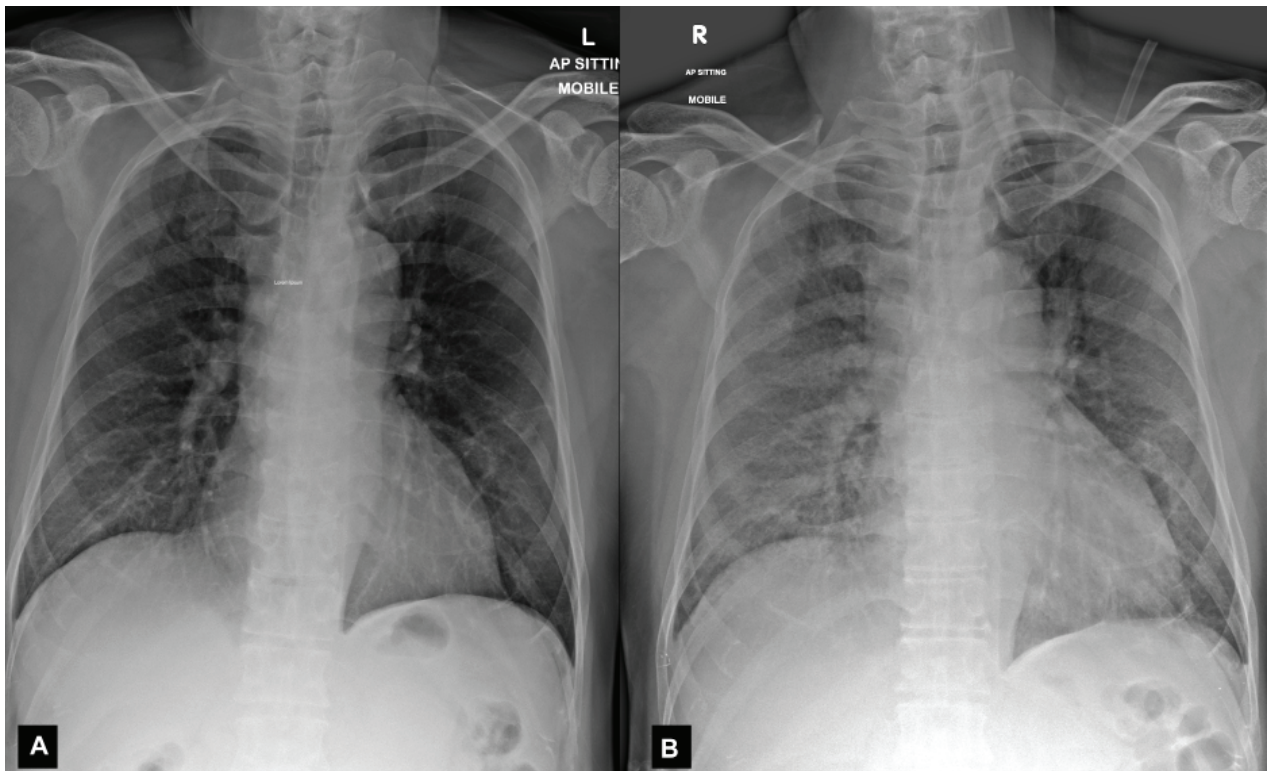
A: On admission, chest radiograph showed minimal ground-glass opacities in lower zones with interstitial thickening in right base and atelectasis in left lower zone. No consolidation or pleural effusion was evident. B: On day 2, repeat chest radiograph showed rapid development of diffuse ground-glass opacities bilaterally. The patient was intubated on the same day.
